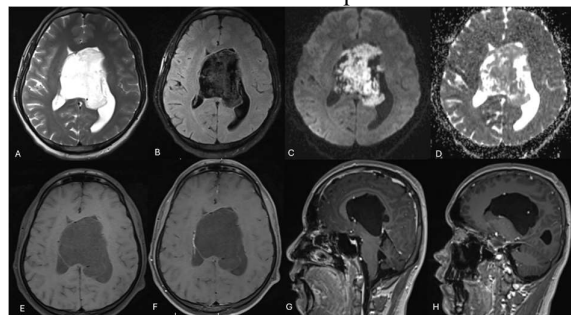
Thirty-six-year-old man with progressive memory impairment. Magnetic resonance imaging of the brain demonstrates a large lobulated midline cystic lesion centered in the cavum septum pellucidum. (a) Axial T2-weighted image shows a hyperintense cystic lesion with thinning of the corpus callosum and bilateral lateral ventricular compression. (b) Axial fluid-attenuated inversion recovery image shows heterogeneous incomplete suppression (“dirty cerebrospinal fluid” appearance). (c) Axial diffusion-weighted image demonstrates marked restricted diffusion within the lesion. (d) Axial apparent diffusion coefficient map shows correspondingly low values. (e) Axial pre-contrast T1-weighted image demonstrates the hypointense midline lesion. (f) Axial post-contrast T1-weighted image shows no appreciable enhancement. (g) and (h) Sagittal post-contrast T1-weighted images demonstrate the full craniocaudal extent of the lesion, with superior displacement and thinning of the corpus callosum, midline ventricular compression, and no appreciable enhancement of the lesion.
